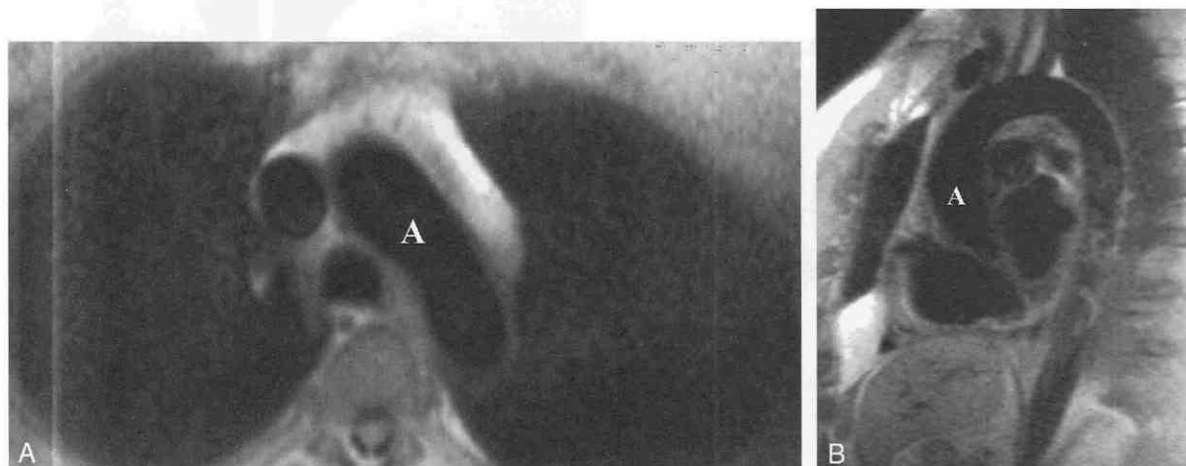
A, Axial half-Fourier acquisition single-shot turbo spin echo (HASTE) MR image of the thoracic aorta shows a signal void within the aortic arch, similar to that shown in Fig. 31-10A. Compared with standard T1-weighted MR imaging, evaluation of the surrounding anatomic structures on this HASTE image is limited. B, Sagittal HASTE MR image of the thoracic aorta displays anatomic information comparable to that shown in the standard T1-weighted MR images of the aorta, as shown in Fig. 31-10B. As in A, rendering of the surrounding anatomy is limited with the HASTE sequence. A = aorta.
